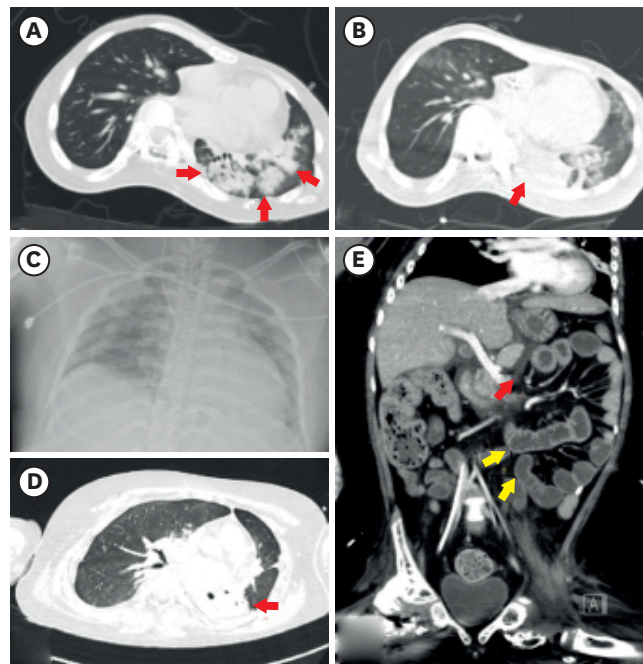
Radiographic findings in three adolescents with coronavirus disease 2019. (A) Chest CT findings of patient 1 one day after the initial symptom; peribronchovascular thickening in LUL lingular division and LLL field suggesting r/o bronchopneumonia (red arrows). (B) Chest CT findings of patient 1 four days after the CPR event; patchy ground glass opacities in right upper lobe, right middle lobe, LUL field with atelectasis in LLL field (red arrow). (C) Chest X-ray findings of patient 2 on the day of CPR event; patchy consolidation in bilateral upper lobe and right lower lobe suggesting r/o pneumonia. (D) Chest CT findings of patient 3 on the day of symptom aggravation (10th day from the initial symptom); atelectasis in LLL (red arrow). (E) Abdomen CT findings of patient 3 on the day of symptom aggravation (10th day from the initial symptom); small amount of peripancreatic fluid collection (red arrow), diffuse fluid filled, dilated small bowel loops with mild bowel wall thickening (yellow arrows). Abbreviations: CT, computed tomography; LUL, left upper lobe; LLL, left lower lobe; CPR, cardiopulmonary resuscitation.
